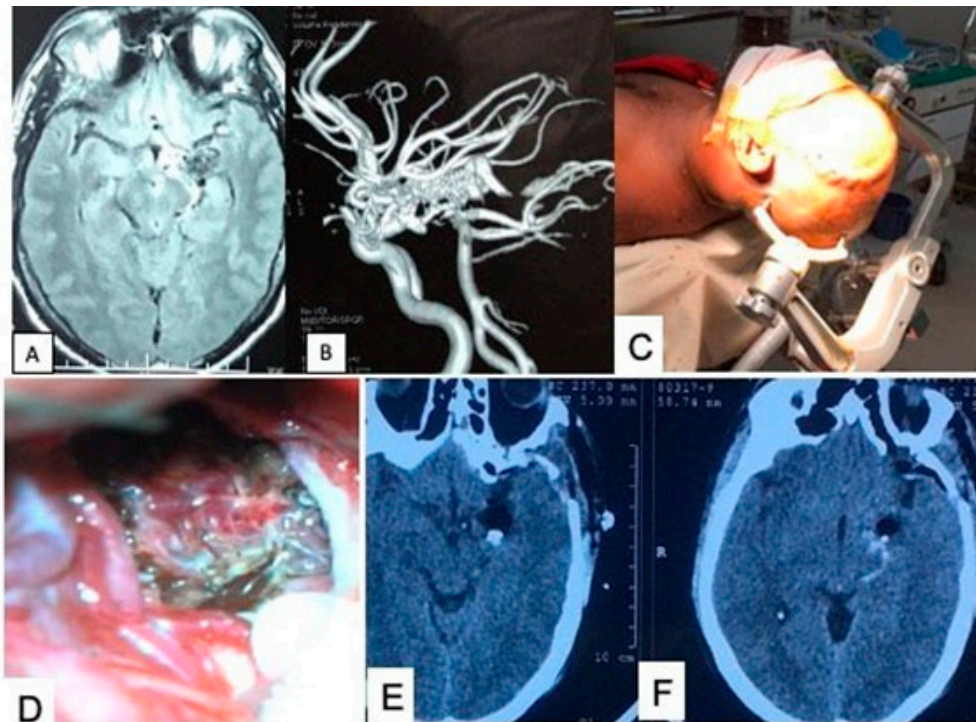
(A,B) MRI and MRA, respectively, showing a left mesial temporal AVM. (C) Patient was in a supine position, with the head end raised and tilting toward the contralateral side. (D) Preoperative picture showing an AVM in the mesial temporal area following the trans-Sylvian approach. (E,F) Postoperative picture showing a resection AVM from the mesial temporal area with a small amount hemorrhage in the temporal lobe. Source: Figure by authors.
